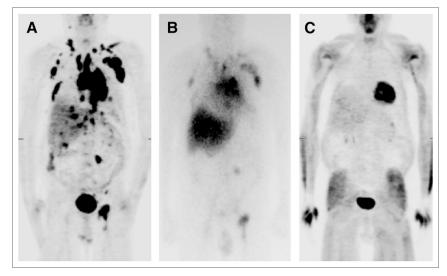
Follicular lymphoma in 61-y-old patient with relapsing disease after 4 previous regimens. He was treated with ¹⁷⁷Lu-DOTA-rituximab, 740 kBq/m², in September 2002. (A) ¹⁸FDG PET shows disseminated, partly bulky relapsing disease. (B) ¹⁷⁷Lu scintigram 4 d after ¹⁷⁷Lu-DOTA-rituximab depicts distribution of ¹⁷⁷Lu in tumor masses. (C) Repeated ¹⁸FDG PET 2 mo after radioimmunotherapy shows complete remission. Patient has remained in remission since.
